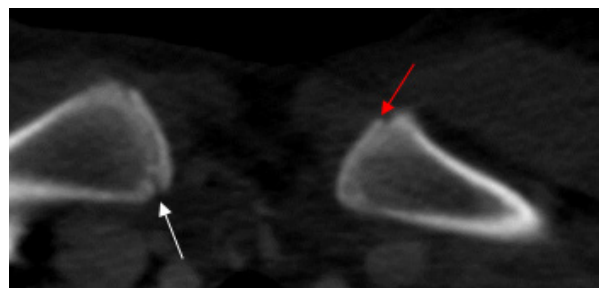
CT image 18 year old female shows stage 3a ossification (white arrow) of the right and stage 3b of the left epiphyseal cartilage (red arrow)
